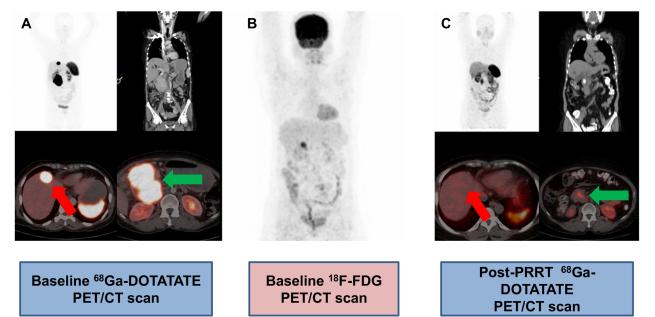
A 56 years old women, known case of unresectable pancreatic NET with single liver metastatic lesion. Baseline ⁶⁸Ga-DOTATATE PET/CT scan (A) showed intensely somatostatin receptor avid unresectable primary pancreatic lesion (measuring 8.0x8.8 cm) involving PV/SMV (> 180°) and intensely somatostatin receptor avid single metastatic lesion measuring 2.5x2.8cm in segment IV of the liver. Baseline ¹⁸F-FDG PET/CT scan (B)showed absent FDG uptake in primary and metastatic liver lesion. Patient received 5 cycles of PRRT (total cumulative dose=33.3GBq). Post -PRRT, ⁶⁸Ga-DOTATATE PET/CT scan (C) showed complete morphological disappearance of metastatic liver lesion and significant reduction in size and ⁶⁸Ga-DOTATATE uptake of pancreatic lesion with no major abdominal vessels involvement and primary became resectable. Post-PRRT, patient underwent whipples procedure without any major complication in peri-operative period and on subsequent follow up period.
